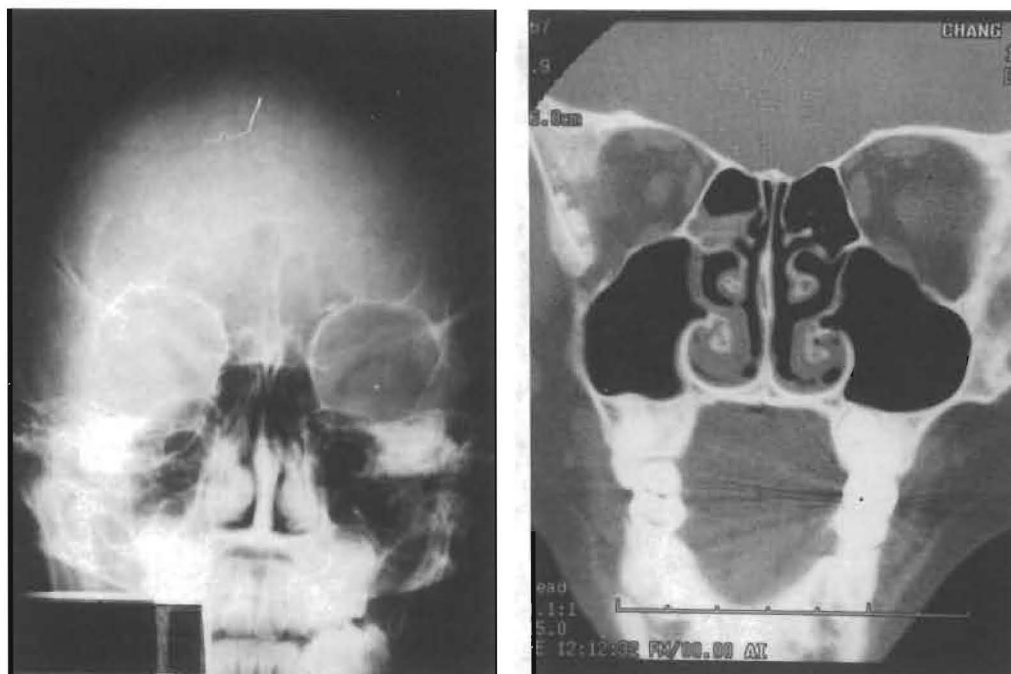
A: Caldwell projection radiograph in an 8 year-old girl was interpreted as showing normal ethmoidal sinuses bilaterally; B: Representative coronal CT scan shows abnormal right ethmoidal sinus.
